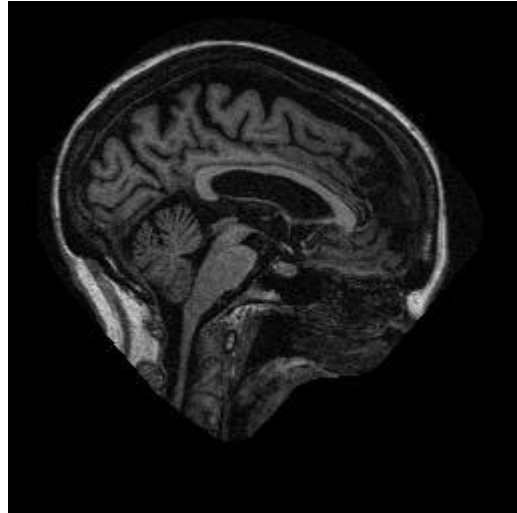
A representative MR image of an AD subject (CDR = 1)
